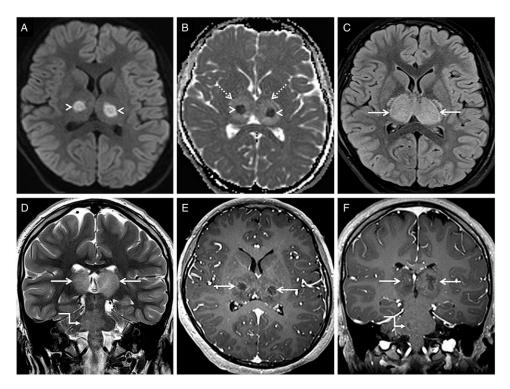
MRI in an 8-year-old patient presenting with fever and decreased level of consciousness. The patient tested positive for COVID infection. Axial DWI (A) and apparent diffusion coefficient (ADC; B) show areas of restricted diffusion involving both the thalami (arrowheads) with peripheral areas of facilitated diffusion (dotted arrows in B). Axial FLAIR (C) and coronal T2-weighted (D) sequences demonstrate marked swelling of the thalami (arrows). In addition, confluent T2-weighted hyperintensity is seen in the pons (stepped arrow in D), extending into the medulla. Corresponding FLAIR hyperintensity was noted in the affected brainstem (not shown). Contrast-enhanced axial (E) and coronal (F) 3D-T1 sequences show faint irregular enhancement in the thalami (arrows), with a nonenhancing core, corresponding to the areas of restricted diffusion. Subtle, irregular, ring-like enhancement is also seen in the right hemipons (stepped arrow in F). These imaging manifestations suggest a parainfectious CNS complication (ANE) following COVID-19 infection occurring due to a hyperimmune response. ANE = acute necrotizing encephalopathy; CNS = central nervous system; DWI = diffusion-weighted imaging.
